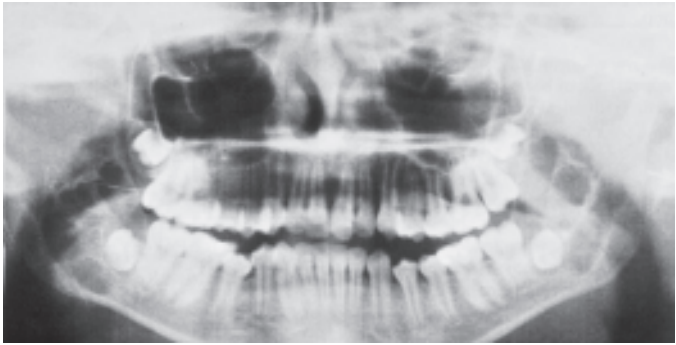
Panoramic radiographic appearance of multilocular intraosseous radiolucencies of cherubism
